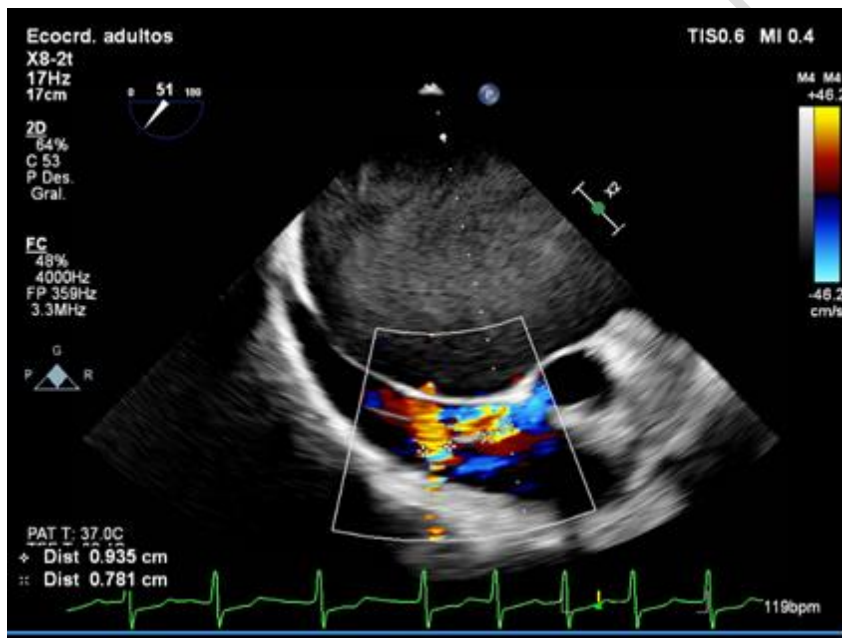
Central jet of moderate tricuspid regurgitation is seen as a flow directed to the atria, with annular dilation not seen on preoperative transthoracic echocardiography
